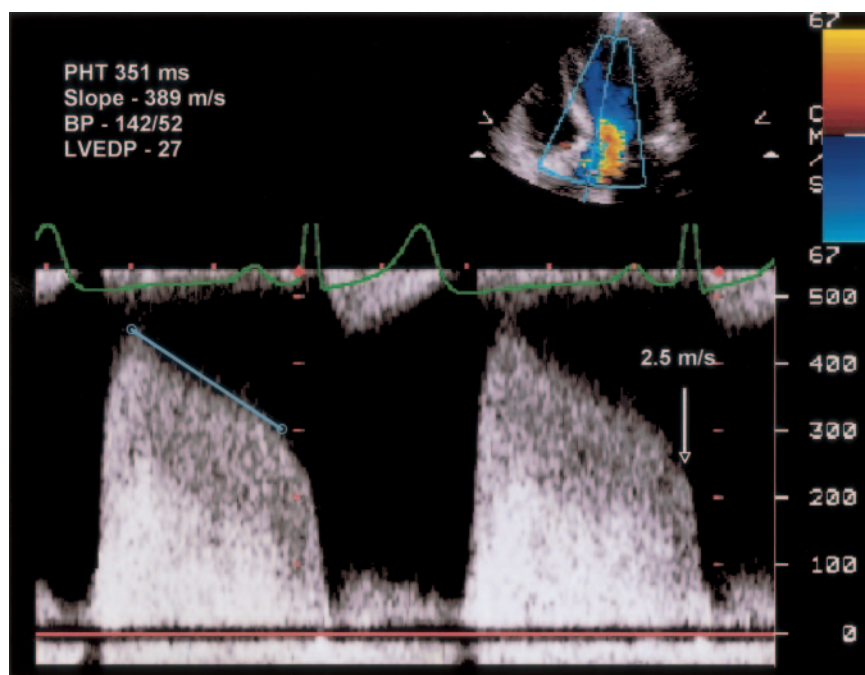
Continuous wave Doppler of AR jet in a patient with moderate AR and a long-standing history of hypertension. The slope of velocity deceleration is fairly steep, with a pressure half-time (PHT) of 351 ms. LV end-diastolic pressure (LVEDP) can be calculated by converting end-diastolic velocity (measured at the R wave peak) to pressure gradient by $4V^2$ and subtracting this value from the diastolic blood pressure (BP). Patients with chronic compensated AR may have a relatively flat slope, reflecting a compliant LV with a normal or only slightly elevated LVEDP.
